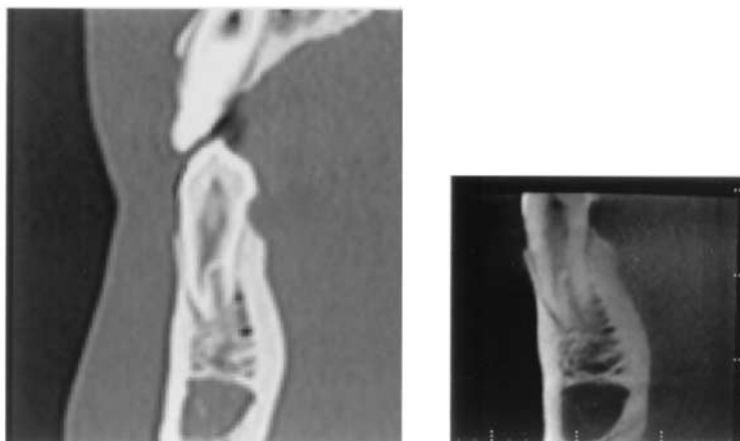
Images taken with the multidetector CT machine (*left*) and the 3DX machine (*right*) of the left mandibular first molar (images taken at magnification equivalent to that of image 2).
